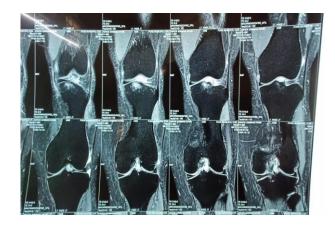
MRI showing coronal section of mucoid degeneration of ACL.
